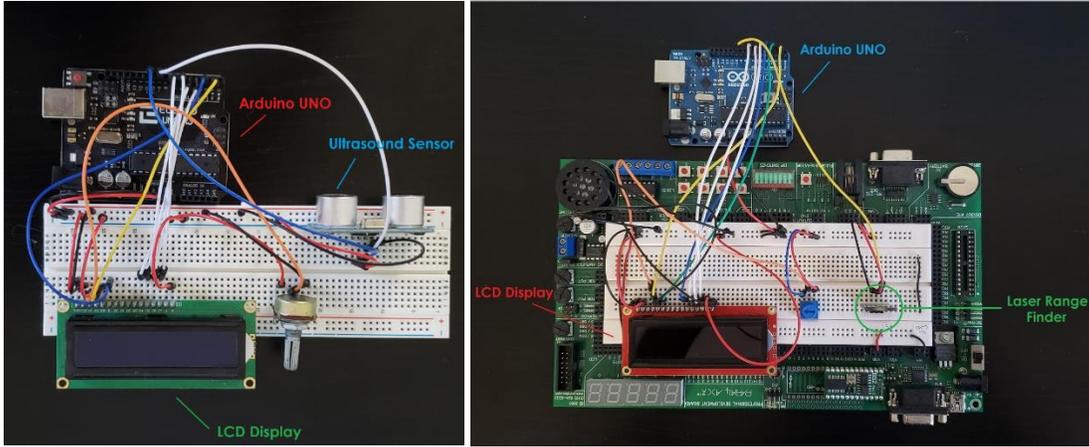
The Ultrasonic sensor and Laser Range Finder setups used to make measurements
